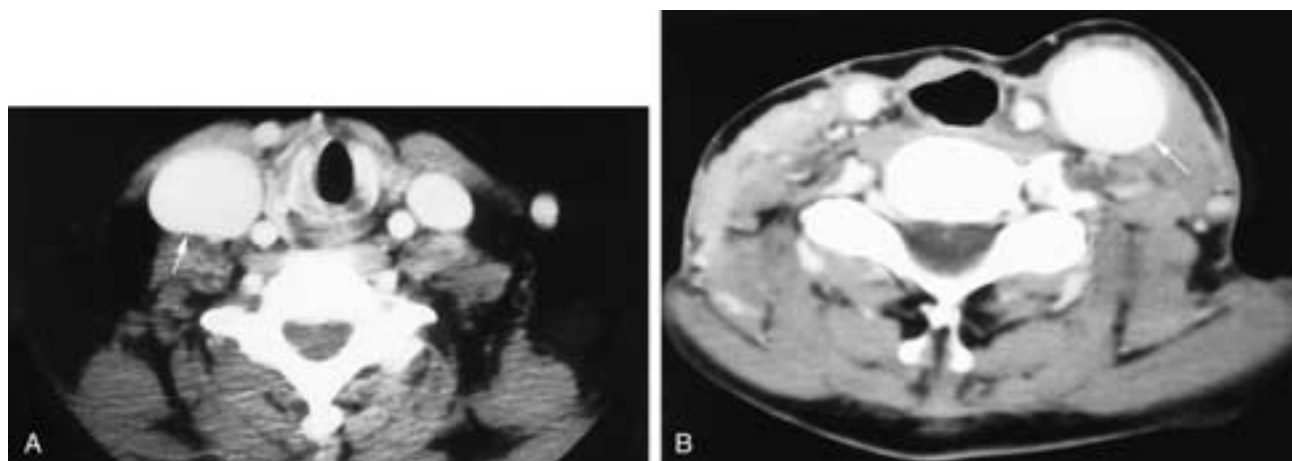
Axial contrast-enhanced CT scan (A) shows a large but normal right internal jugular vein (*arrow*). In about 80% of patients, the right internal jugular vein is dominant. Axial contrast-enhanced CT scan (B) of a patient who has had a right radical neck dissection. The right internal jugular vein was resected, and the left internal jugular vein (*arrow*) has become enlarged.
